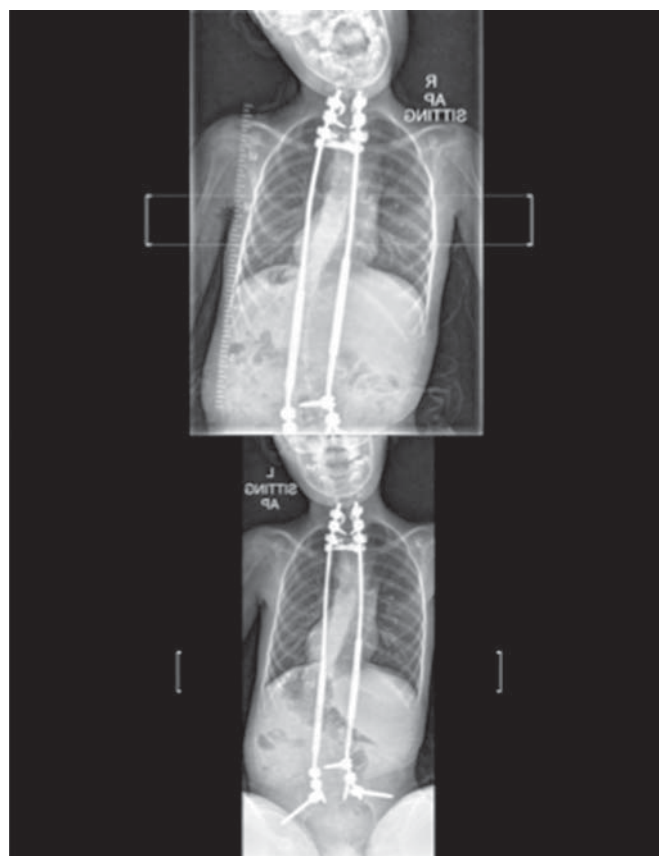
AP radiographs after fifth and sixth distractions (19 and 23 mo). AP indicates anteroposterior.
